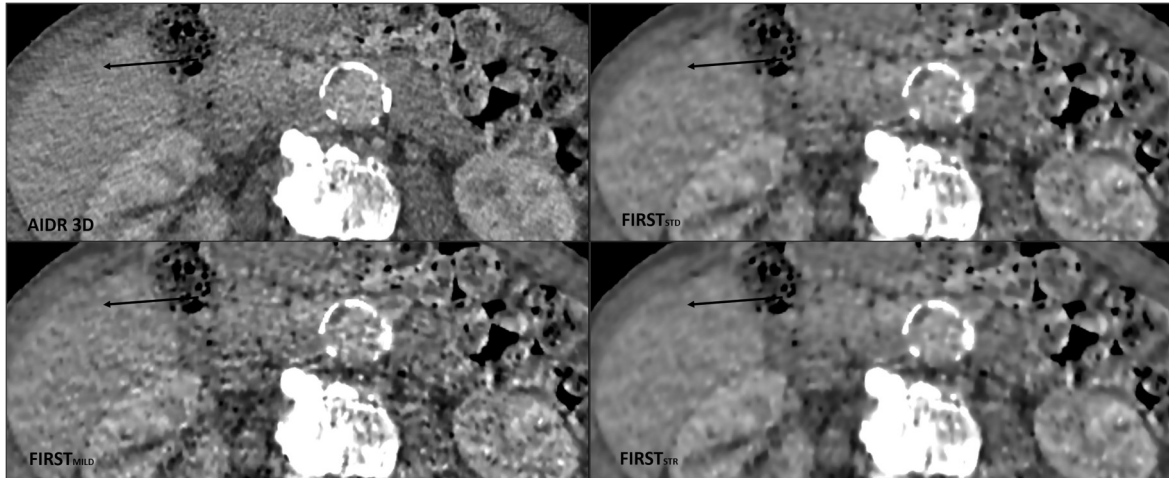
Axial computed tomography images showing a very low-contrast lesion (black arrows) with liver-to-lesion contrast of 13.60 HU in AIDR-3D, increasing to 16.63 HU in FIRST_{MILD}.
